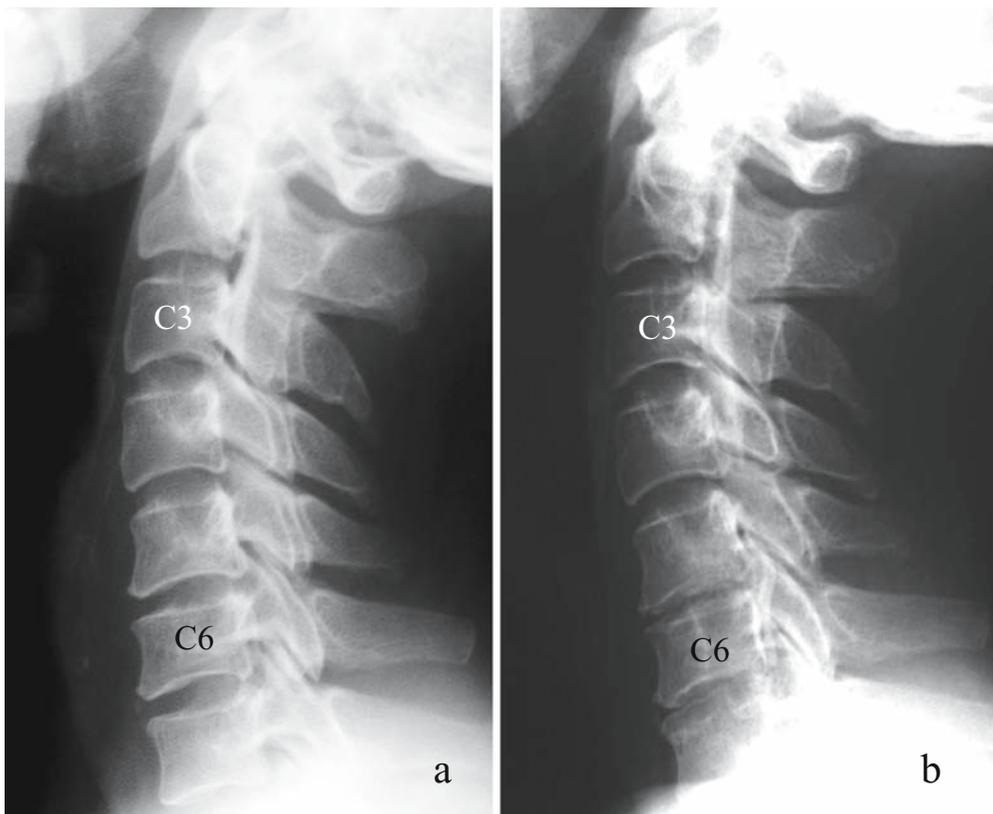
Natural progression of cervical OPLL in a 55-year-old man. a Cervical lateral radiograph shows continuous-type OPLL extending over C2 and C3 and segmental-type OPLL at C6. b Radiograph obtained 11 years after the first radiograph
